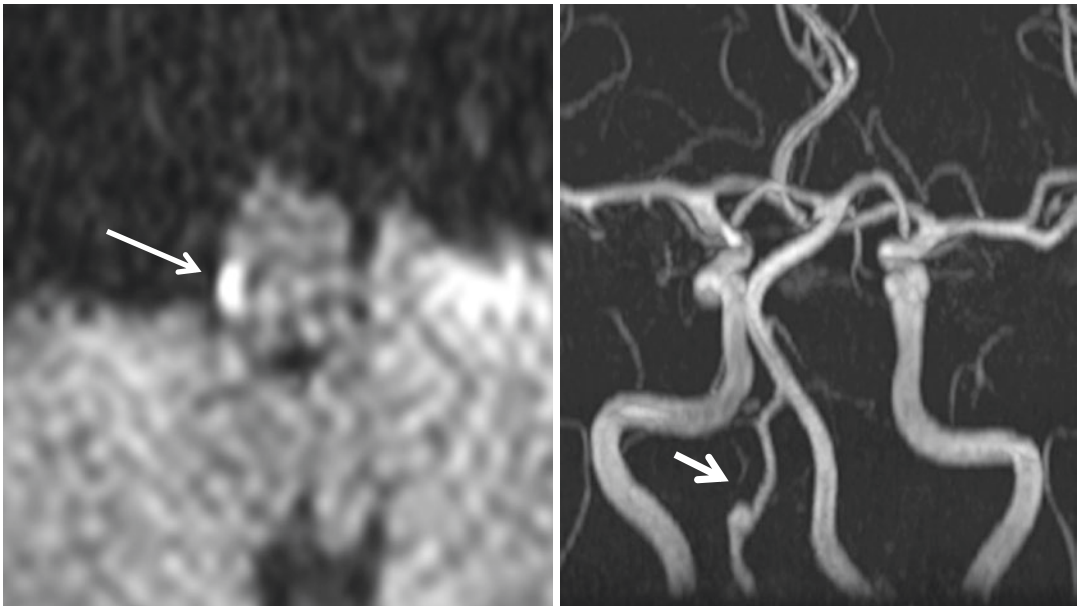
A 35-year-old woman suddenly developed dizziness, gait instability, and sensory deficits in the left lower limb preceded by posterior neck pain for 3 days. Diffusion-weighted MRI showed a right caudal lateral
